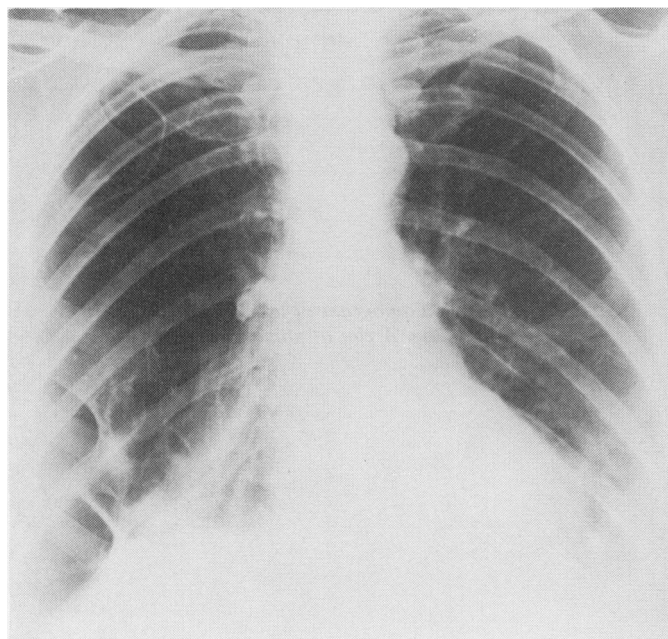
Patient 1. Chest radiograph showing extensive bullae; there is probably a pneumothorax at the right base.
